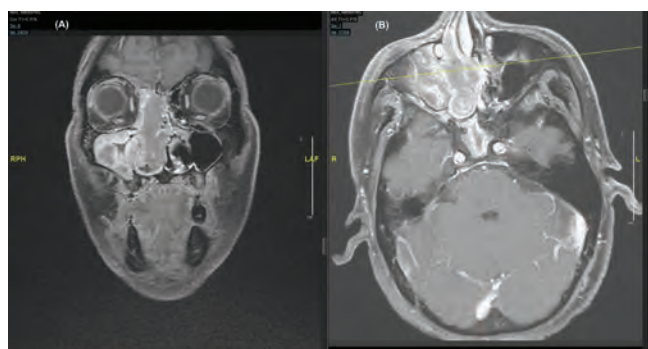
Coronal (A) and axial (B) views of T1-weighted magnetic resonance imaging with contrast.
